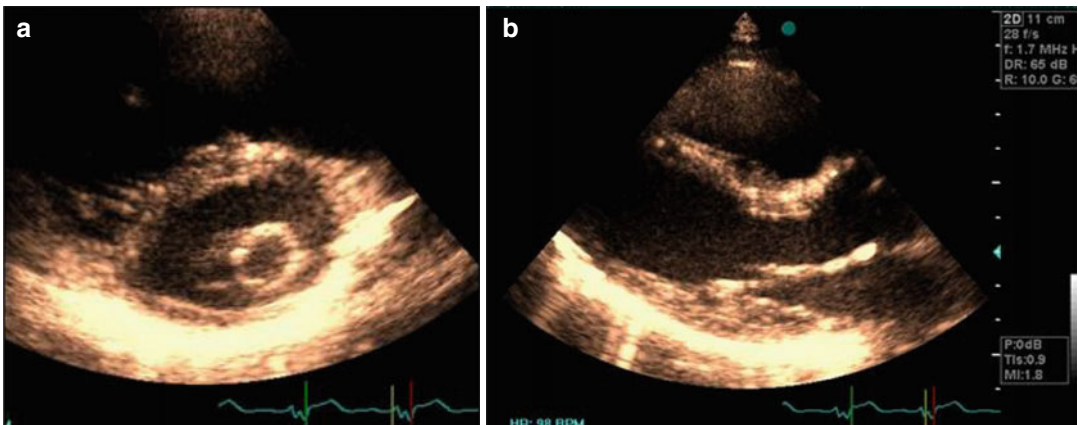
(a, b) Parachute mitral valve with dominant anterior papillary muscle by 2D echocardiography in short- and long-axis views
